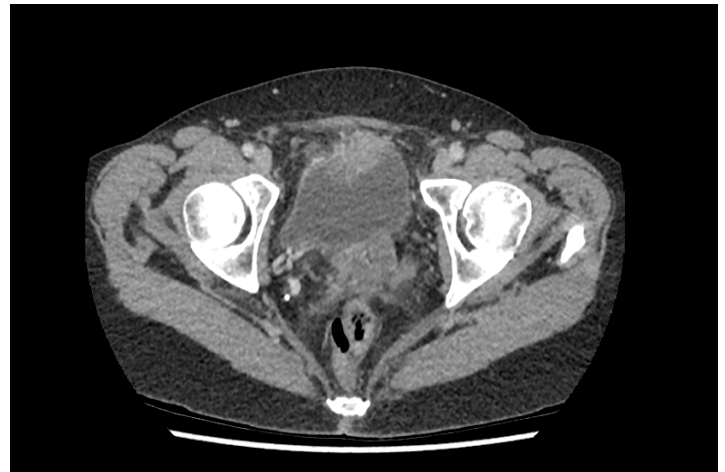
Axial CT image showing a mixed density mass superior to the bladder.
